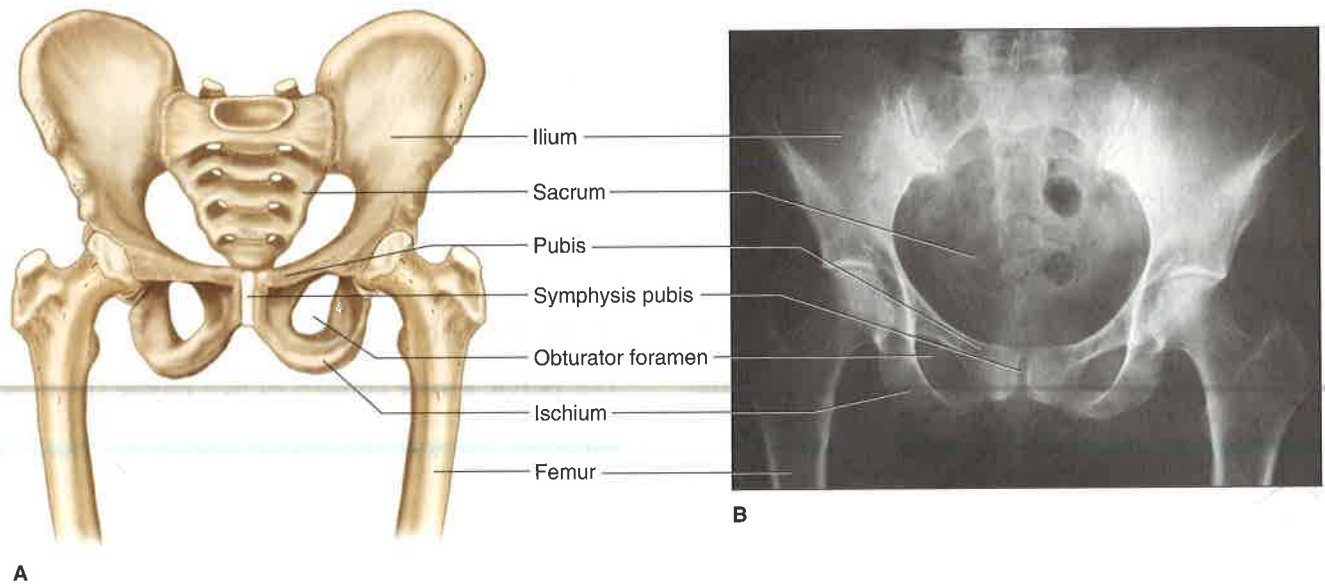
Pelvic girdle. (A) Formed by two coxae, the sacrum, and coccyx. (B) Radiograph of the pelvic girdle.
